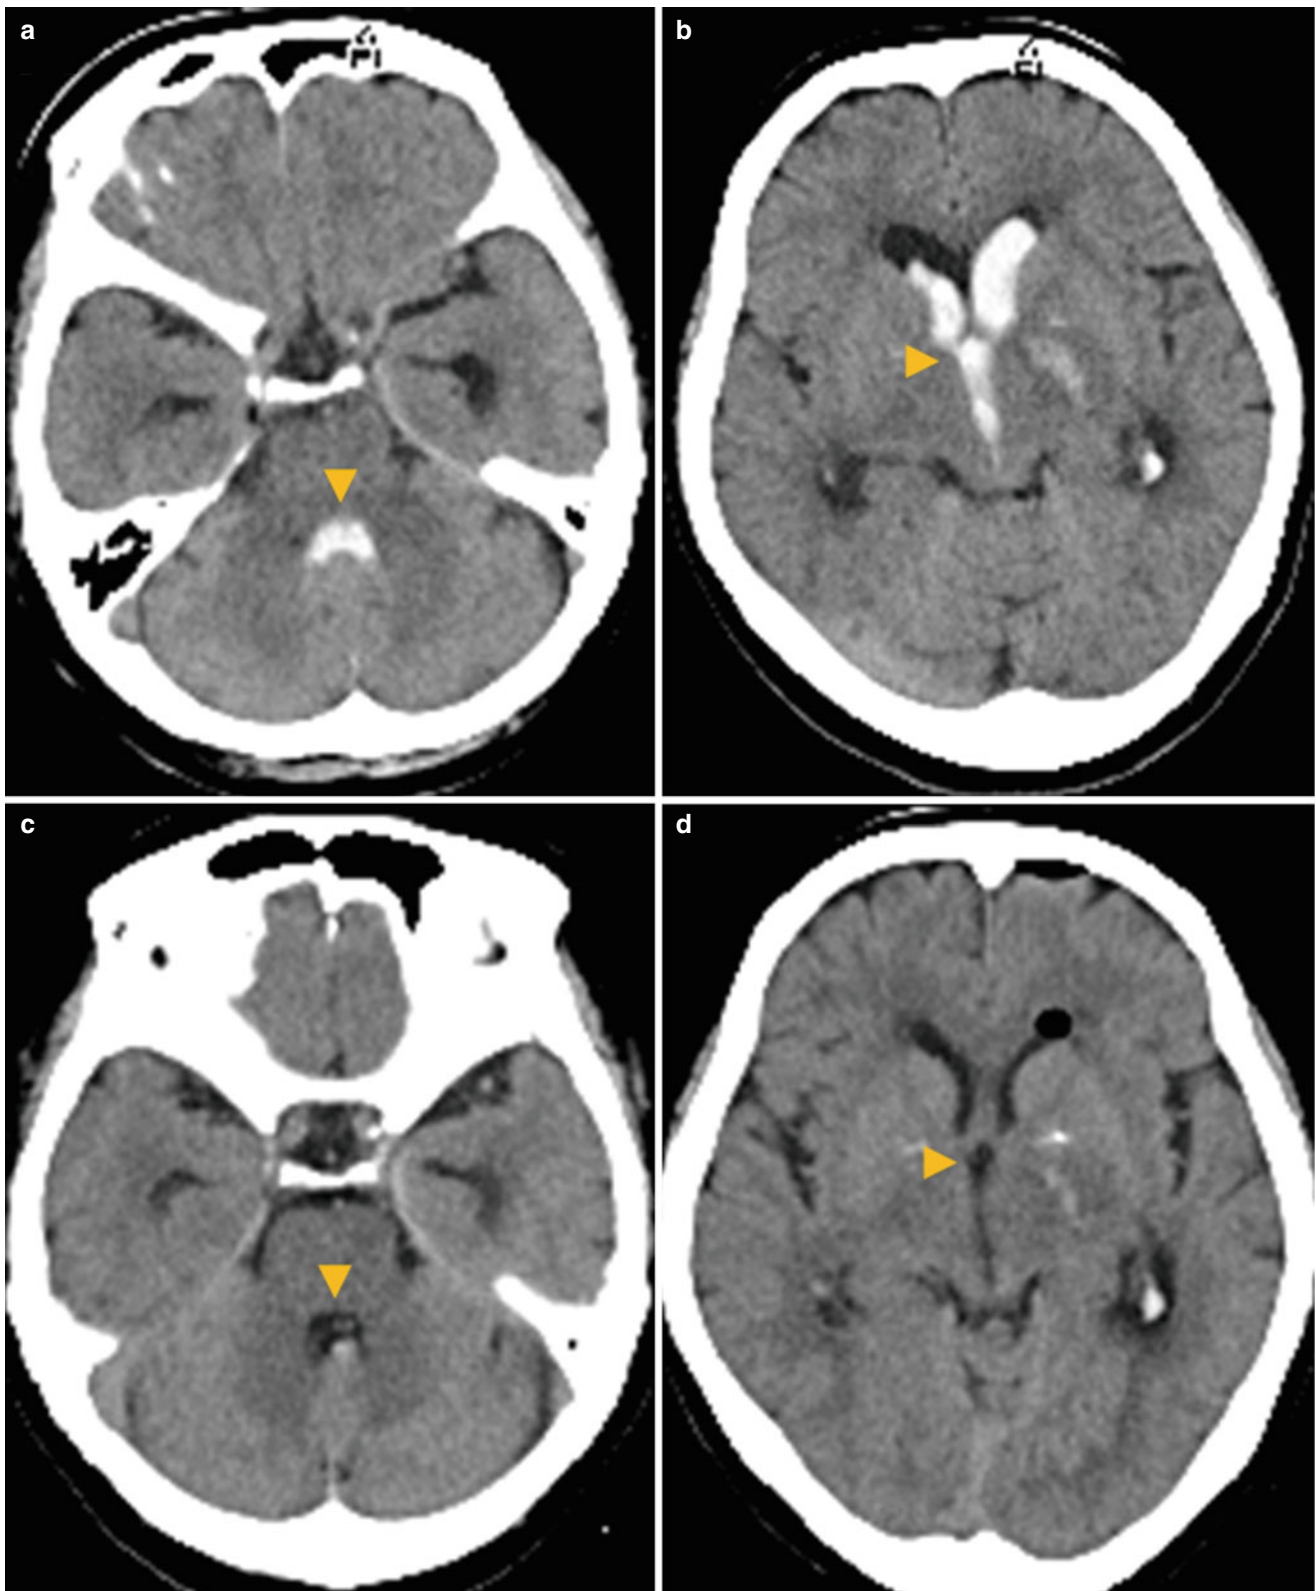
Representative case of flexible endoscopic surgery for intraventricular hematoma due to thalamic hemorrhage. The initial computed tomography (CT) scan showed left thalamic hemorrhage with casting hematoma in the anterior horn of the lateral ventricle, the third ventricle
